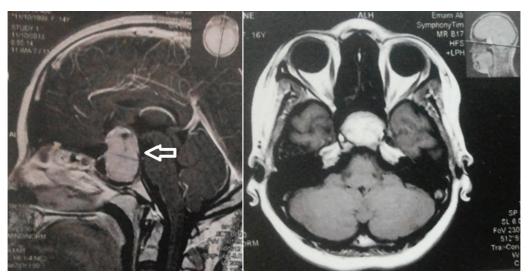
Magnetic resonance imaging (MRI) scan showing a giant adenoma (white arrow).
